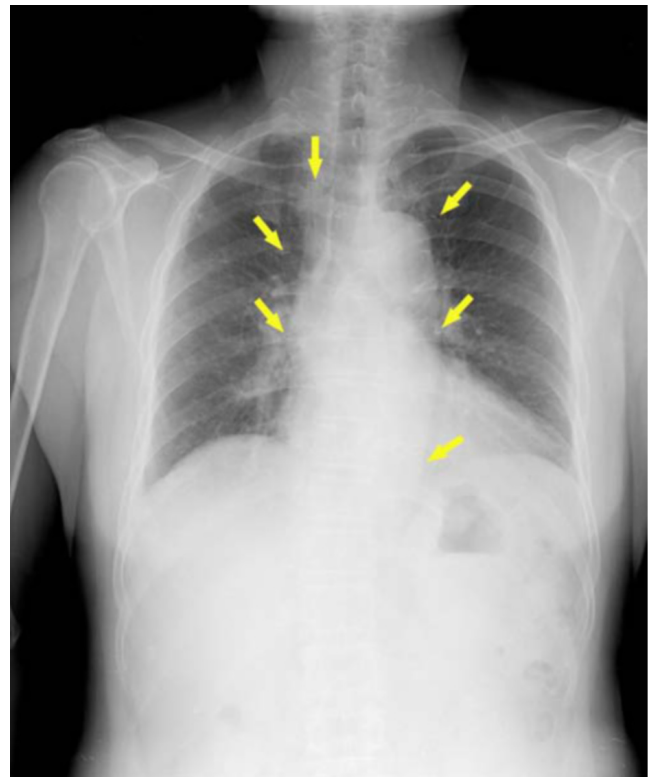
Posteroanterior radiograph of the chest, showing multiple retained acupuncture needles (arrows) in the soft tissues of the torso. These needle fragments lie mostly along two main acupuncture meridians along the back.
